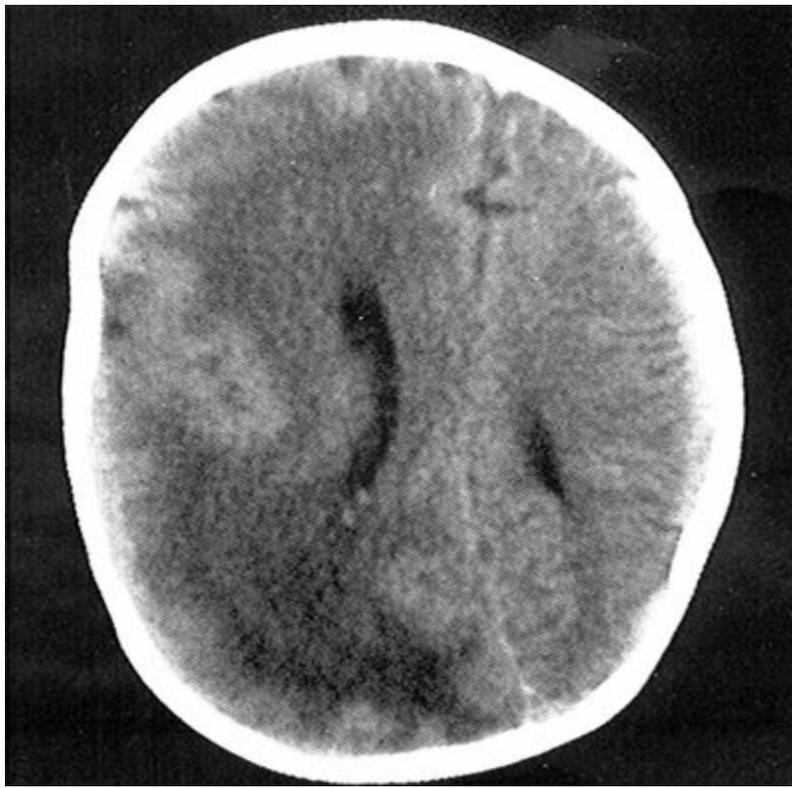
Computed tomography scan of the head showing right hemimegalencephaly with dysplastic and enlarged right cerebral hemisphere. Brain magnetic resonance imaging provides better resolution and definition of the abnormality and reveals subtle involvement of the contralateral hemisphere.
